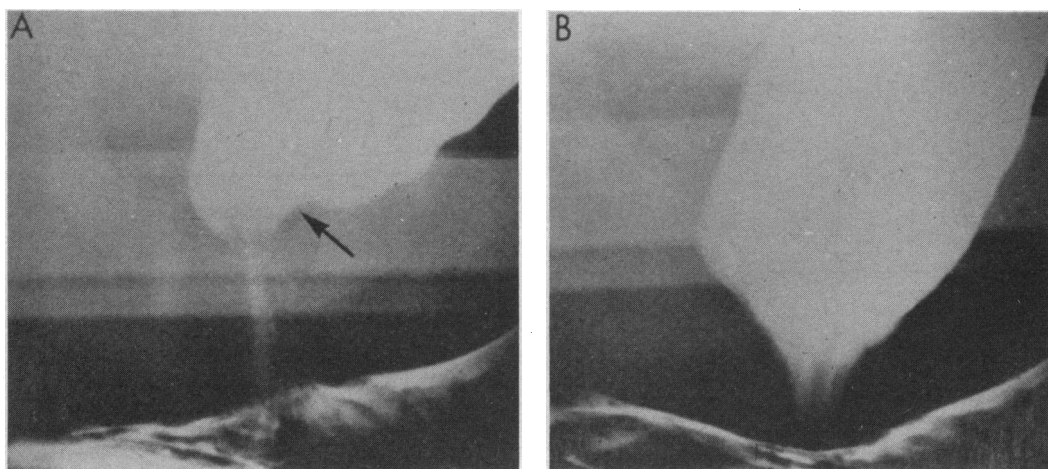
Defaecating proctogram. X-rays of rectum and anal canal showing (A) the relaxed position, with the arrow indicating the puborectalis muscle; (B) the descent of the perineum, shortening and widening of the functional anal canal
